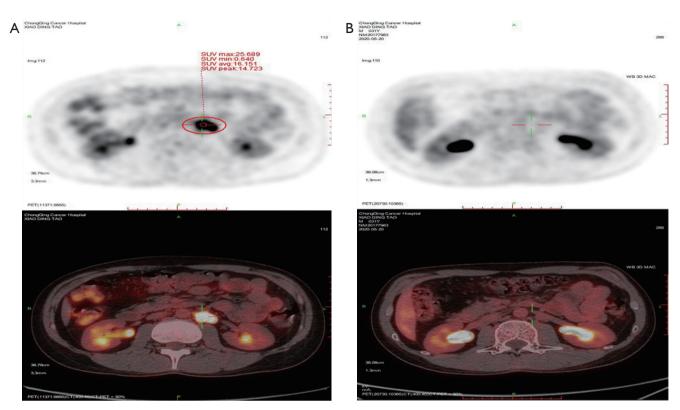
The change of the lesion before and after treatment. (A) The size and SUV of lymph node in the retroperitoneum by PET-CT examination before treatment. (B) PET-CT shows the lymph node in the retroperitoneum disappeared completely after Immune checkpoint inhibitor treatment.
